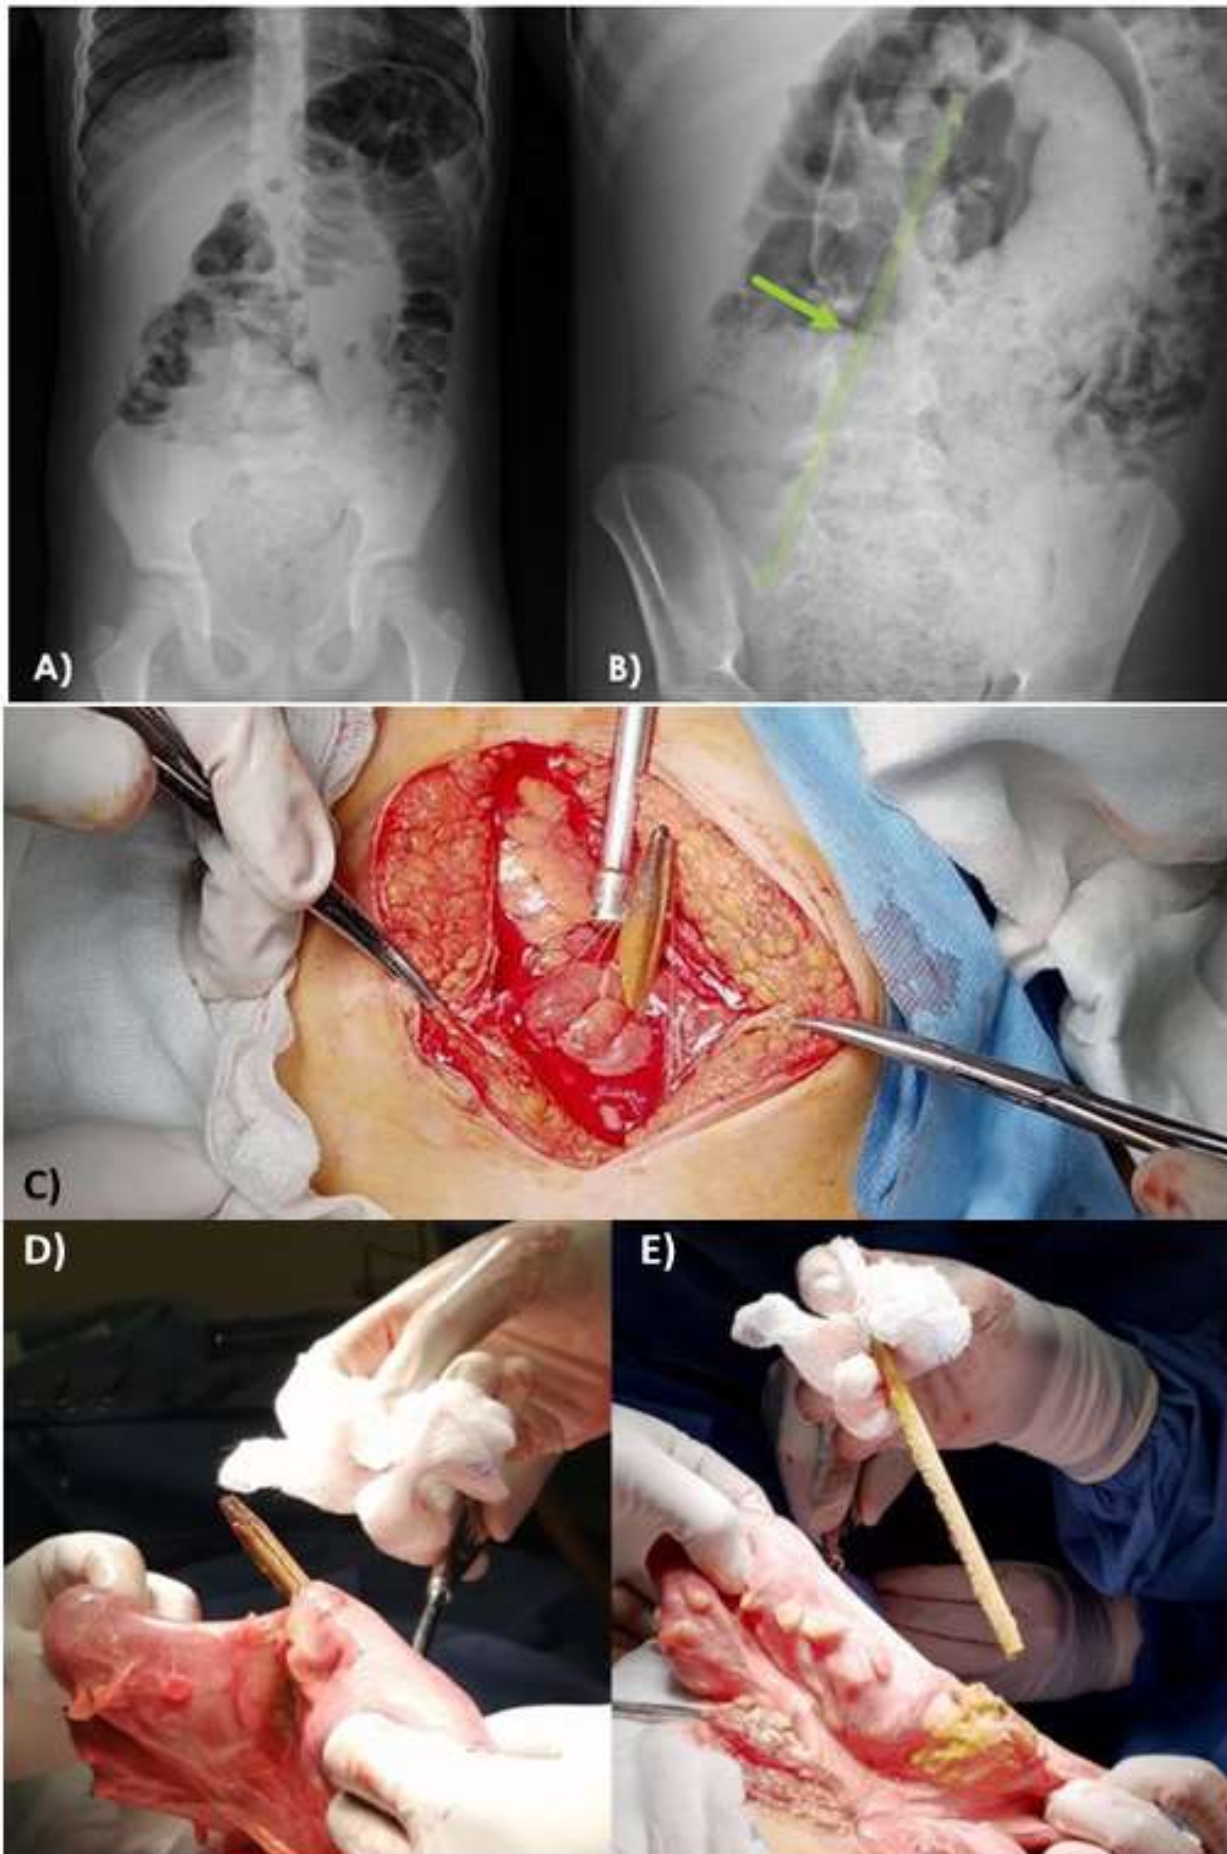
A. AP abdominal X-ray with visualization of coprostasis and dilation of intestinal loops. B. Radiographic image highlighting the foreign body. C. Foreign body (Pencil) found when exploring the abdominal cavity by laparotomy. D. Foreign body at the level of the sigmoid colon, 10 cm from the rectosigmoid junction. E. Removal of the foreign body in its entirety. sigmoid with 10 mm perforation.
